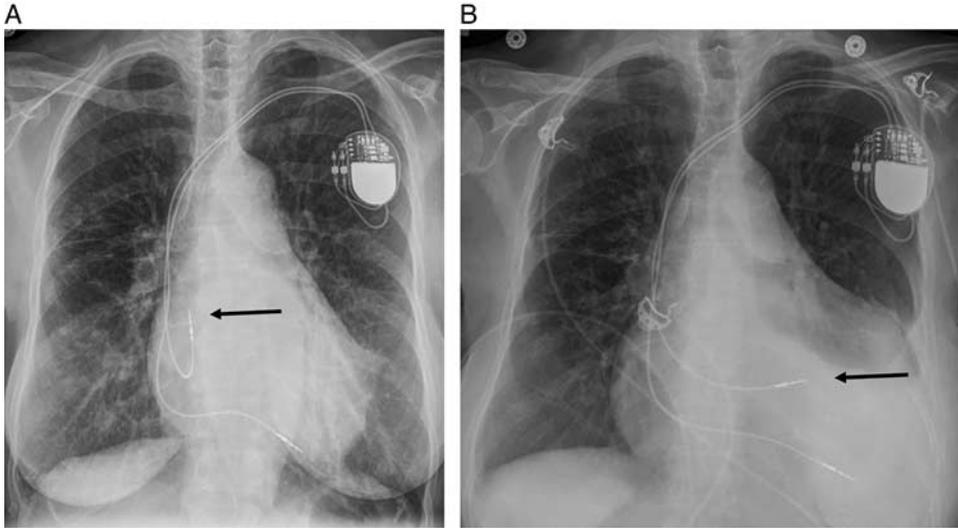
Perforated pacemaker lead: initial (A) and follow-up (B) radiograph of dual-lead pacemaker. Note the dislodged atrial lead (black arrow) and the enlarged cardiac silhouette on follow-up radiograph, consistent with myocardial perforation and resultant hemo-pericardium.
